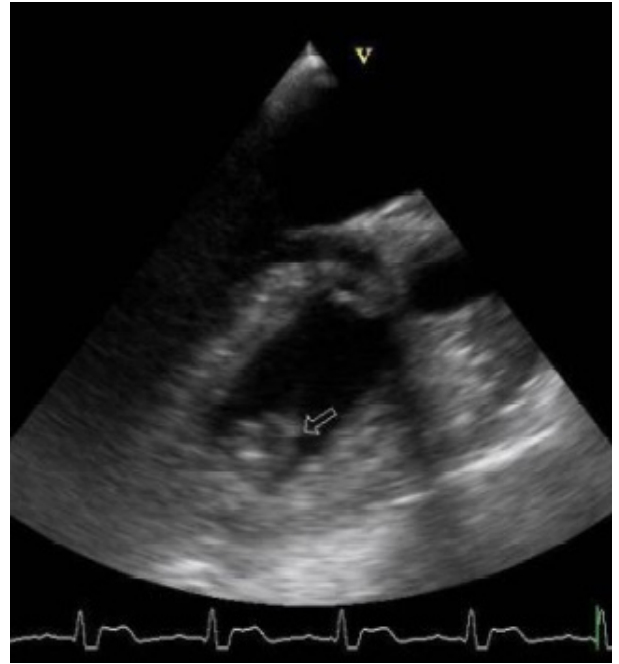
Transeophageal echocardiography. Hypertrophic papillary muscle mimicking mass in right ventricle apex (White arrow).
